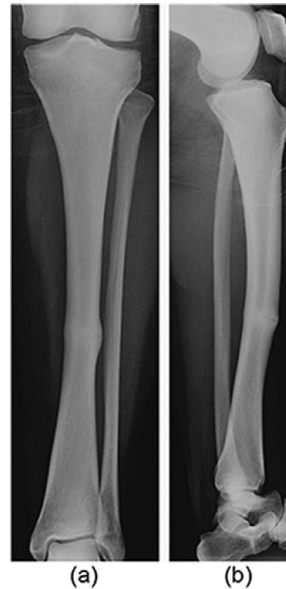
Pyknodysostosis. Anteroposterior (a) and lateral (b) radiographs of the left tibia and fibula show hyperostosis with preservation of the medullary cavity. A subacute fracture is noted in the mid-diaphysis of the tibia, a common finding in patients with pyknodysostosis
